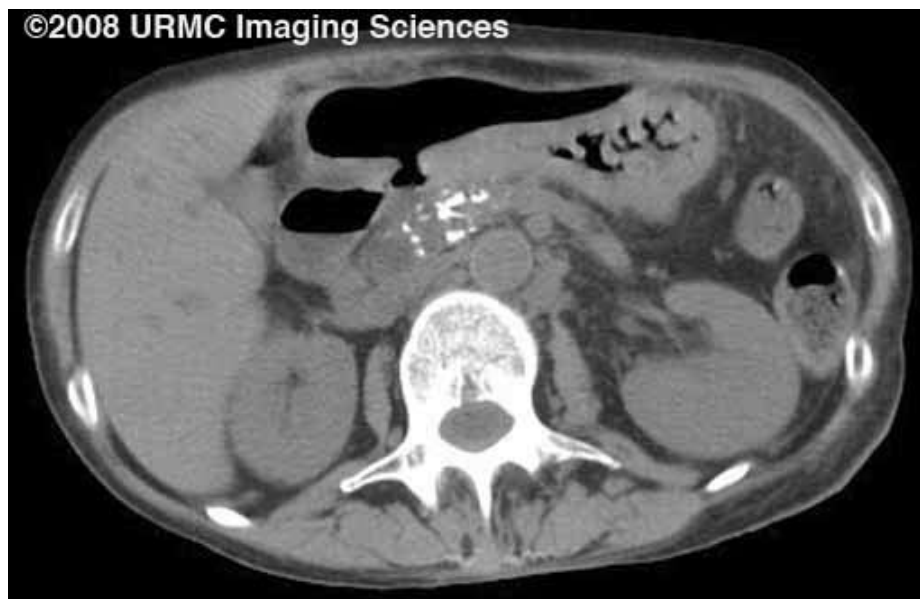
Single axial CT demonstrates an air collection in the anterior abdomen with a visible defect in the adjacent duodenum.
